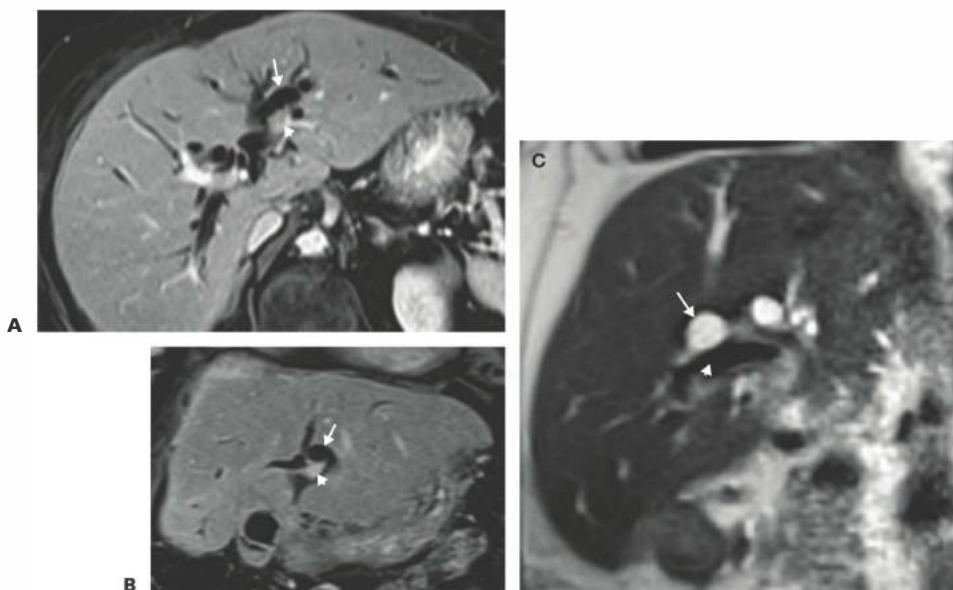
• The segment 3 duct (*white arrowhead*) is located cranial to the left portal vein (*white arrow*) within the umbilical fissure. A. Axial contrast-enhanced portal phase MRI. B. Coronal contrast-enhanced portal vein phase MRI. C. Sagittal T2 weighted MRI.
